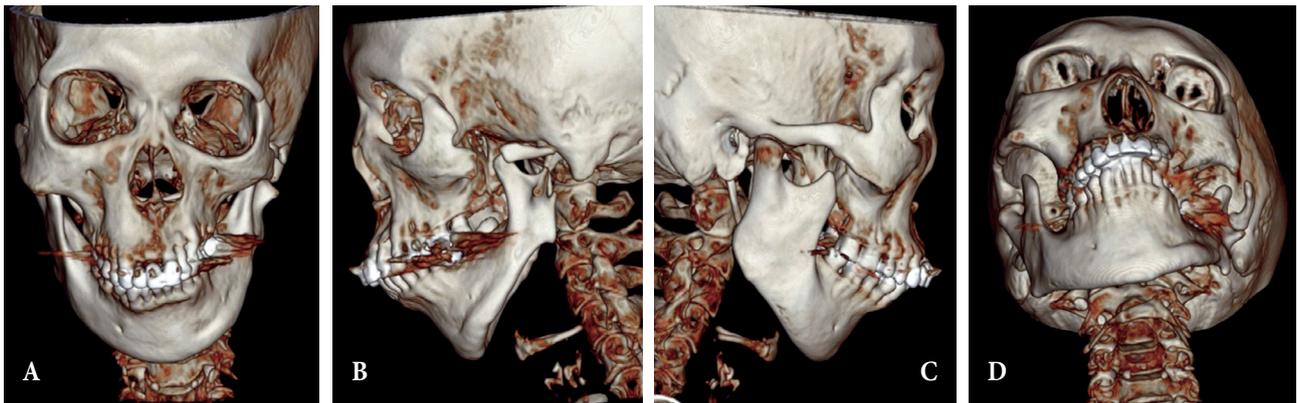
(A–D) Facial three-dimensional computed tomography scan image. Note the severe asymmetry of the facial skeleton and hypoplasia of the left hemiface.
